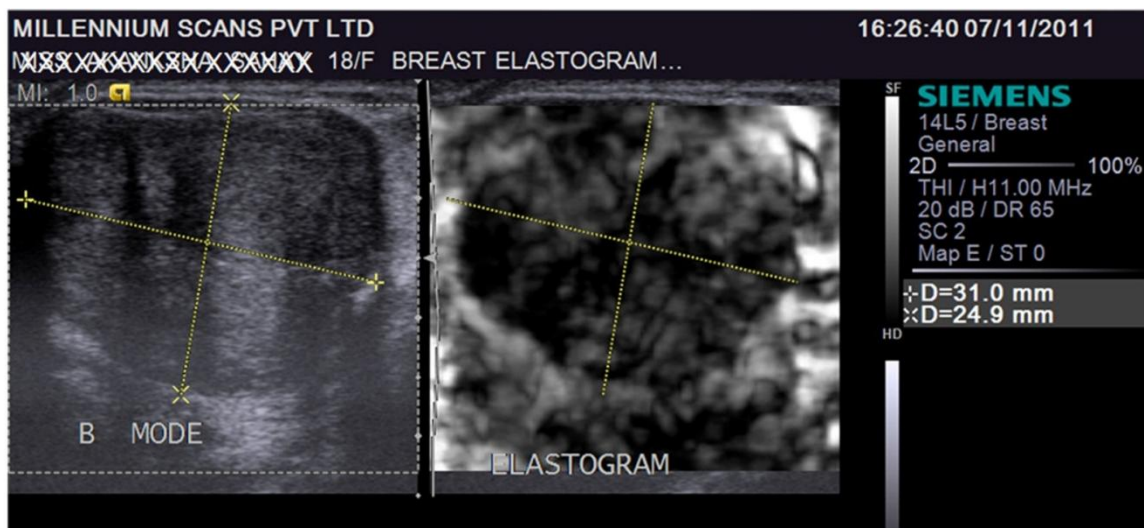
ELASTOSONOGRAPHY OF BENIGN BREAST LESION
